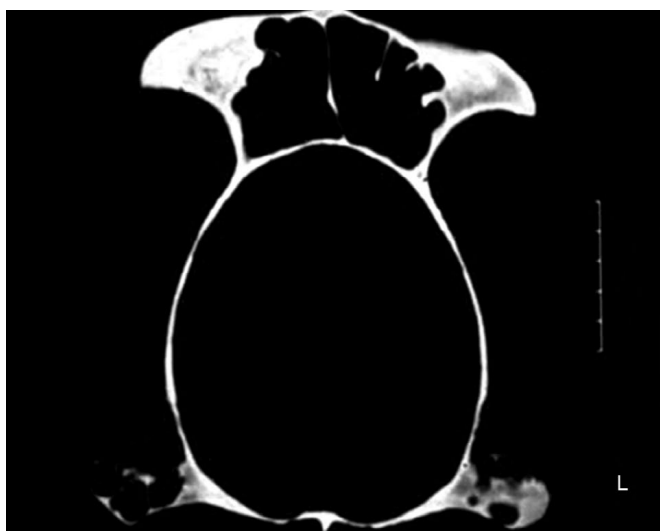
An axial computed tomography scan through a gorilla cranium revealing enlarged, septated frontal sinuses.
